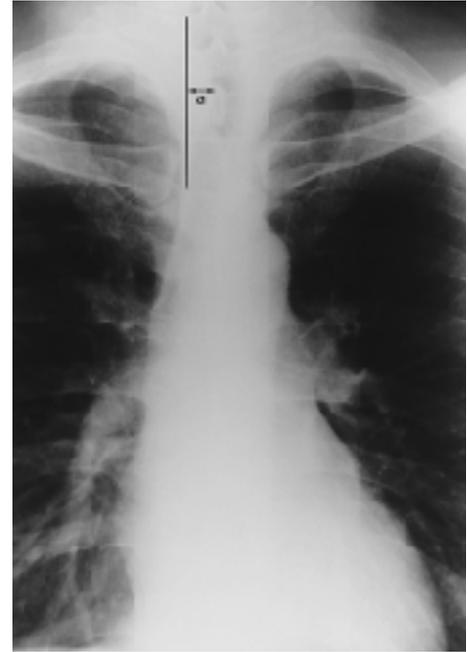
Tracheal deviation was measured on chest PA radiograph. It was measured by the widest distance(a) of the perpendicular line to the line connecting the superior and inferior border of normally located trachea.
